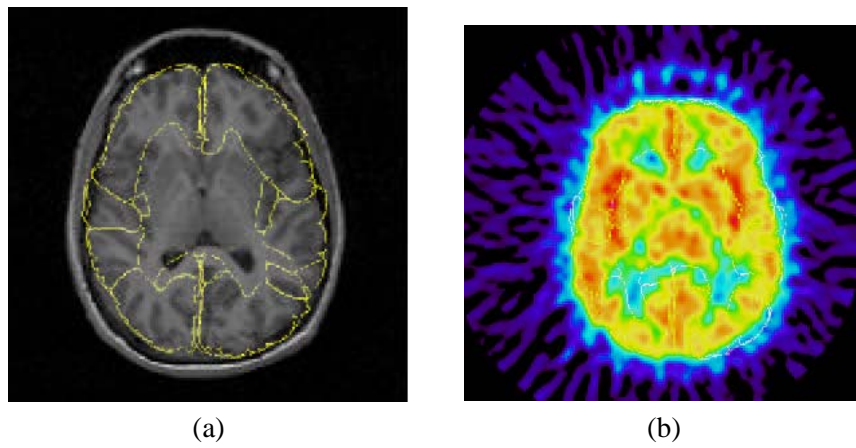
The a) MRI and b) PET volumes with structures from the computerised brain atlas.
